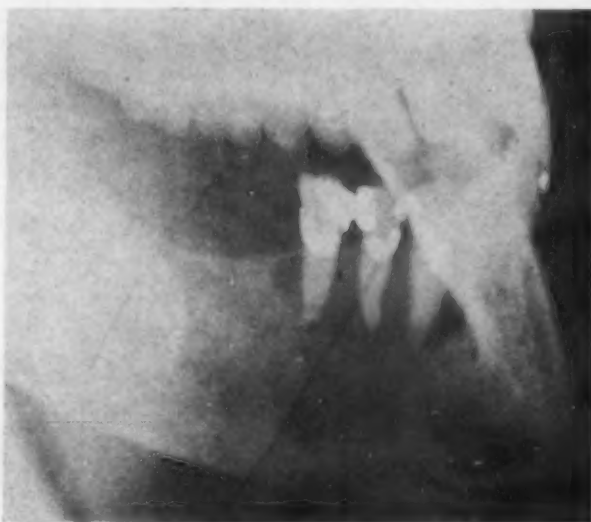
X-ray taken six years before when patient had a giant-cell tumor on the left side of the mandible.
